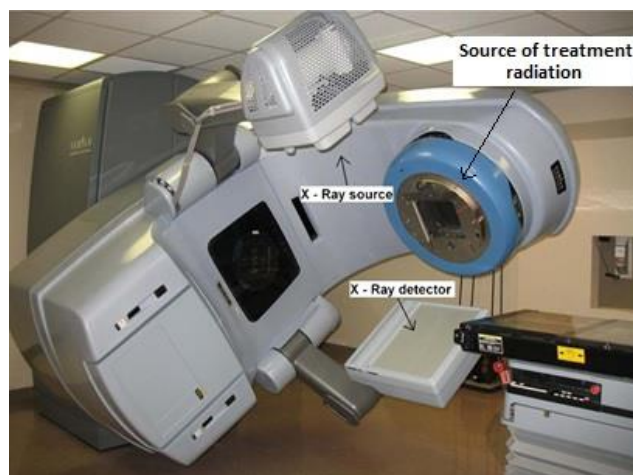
displays a Varian On-board Imaging cone-beam CT (CBCT) unit mounted onto a linear accelerator (LINAC). The auxiliary x-ray source and detector are used to form CBCT images. Adapted from Ding et al., 2007 [63]
